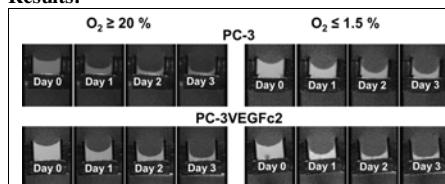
Representative T₁-weighted ¹H MR images of PC-3 and PC-3VEGFc2 cells, both combined with HUVECs on ECM gel demonstrating similar rates of degradation of ECM gel under oxygenation, and increased degradation of ECM gel under hypoxia by PC-3VEGFc2 cells compared to PC-3 cells.
